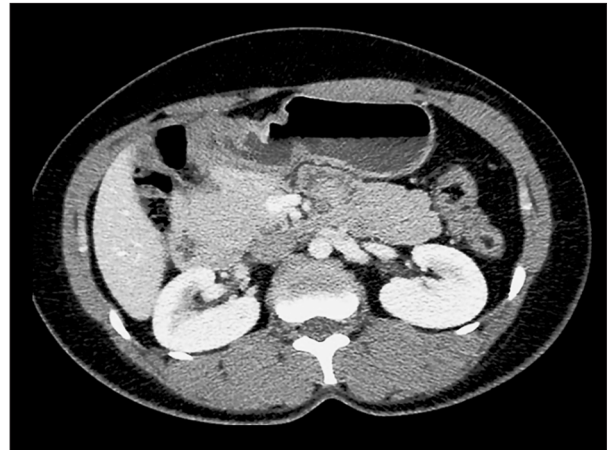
6 months postoperative computed tomography: No recurrent gastric lesion (nonspecific pyloric thickening).
